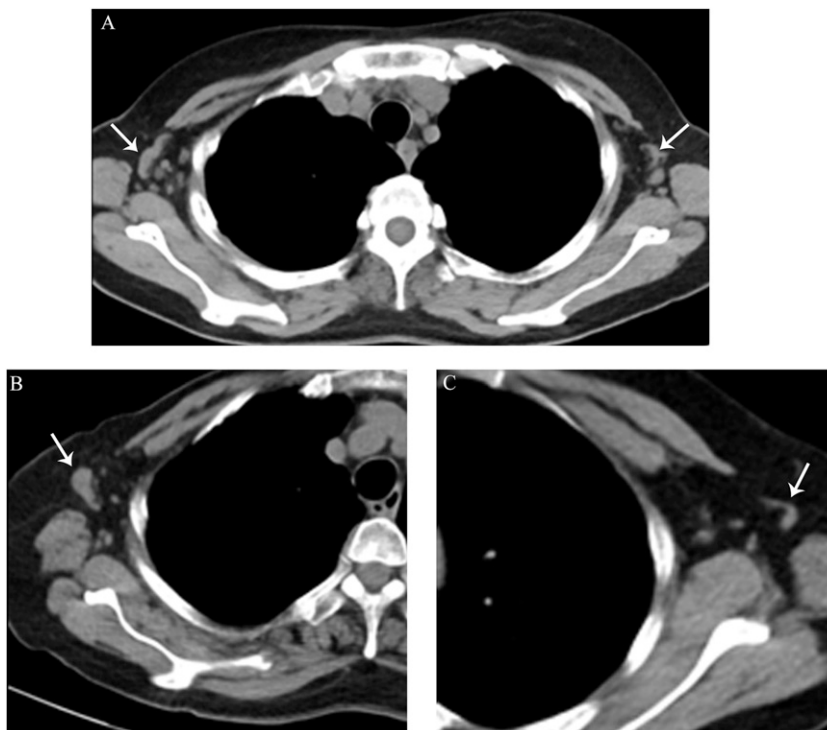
Representative cases showing ALNs in RA and PsA. A Axial chest CT of a 53-years-old female with RA showing bilateral multiple lymphadenopathy (arrow). B Right ALN of a 74-years-old female with RA, showing lymphadenopathy with short axis of 8.1 mm and long axis of 18.9 mm (arrow). C Left ALN of a 73-years-old female with PsA without enlargement (arrow). Length of short axis was 4.5 mm and long axis was 13.6 mm.
